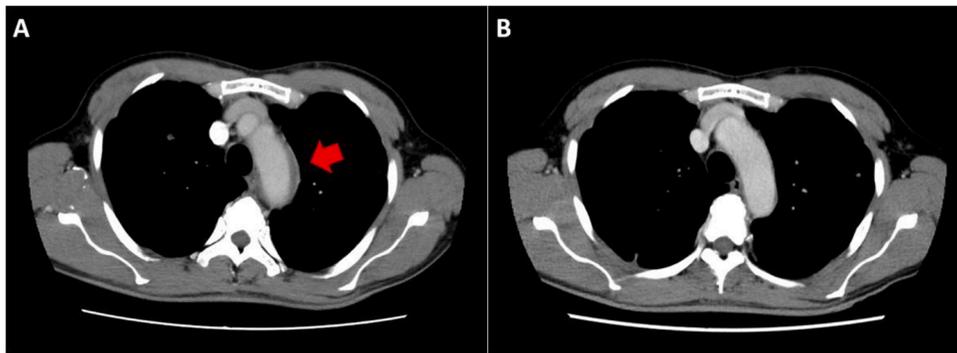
Thoracic aorta imaged by computed tomography (CT) . Images at the time of visit (A) and about 2 months later (B) are shown. (A) Contrast-enhanced CT showed soft tissue thickening around the wall of the aortic arch(arrow). (B) After 2 months, CT showed improvement in wall thickening.
